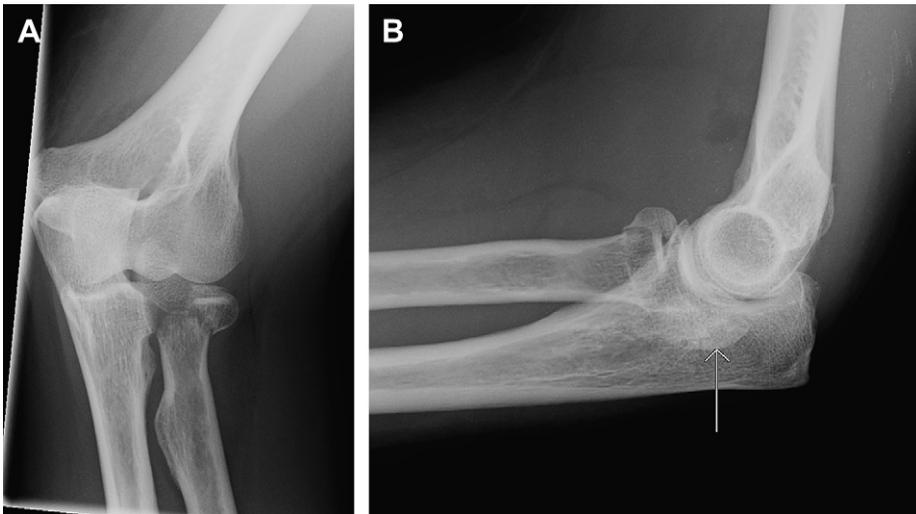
(A) Anteroposterior radiograph of an Essex-Lopresti injury demonstrating a comminuted radial head fracture. (B) On the lateral view, an arrow points out a malrotated and displaced articular fragment. This patient presented with elbow, forearm, and wrist pain.
